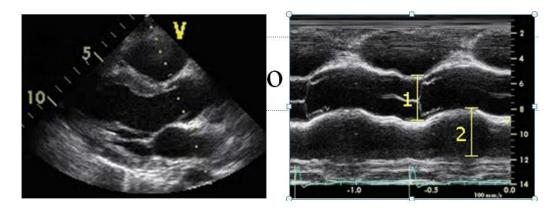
M- Mode echocardiography
